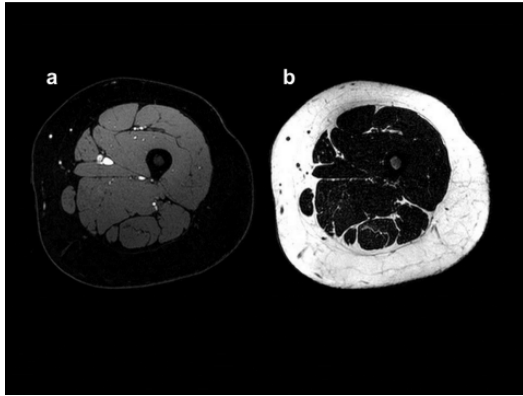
Water (a) and fat (b) only MR images of the thigh of an overweight volunteer
